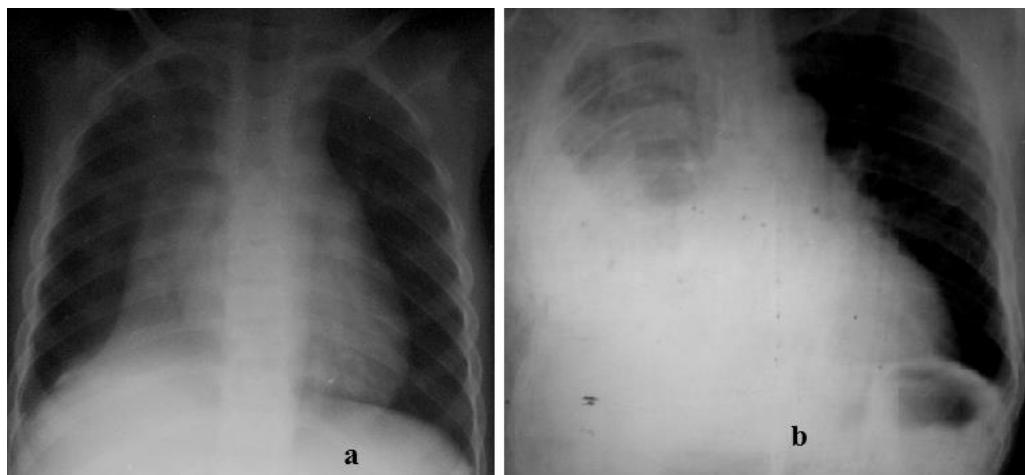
Chest radiographs showing. a. Right lobar collapse. b. Haemothorax in the right middle and lower lobes with contusion of right upper lobe in adult patient with chest trauma as a result of road traffic accident. Note multiple rib fractures in the right upper zone.
